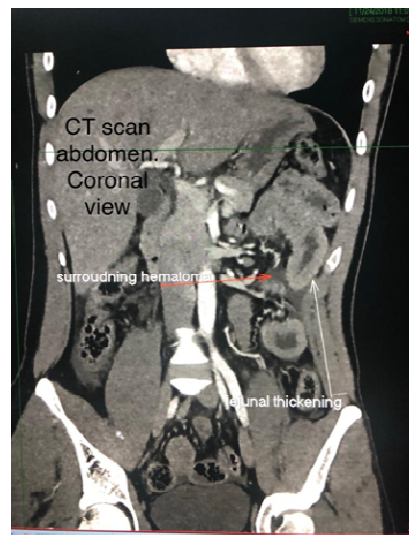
CT scan abdomen Coronal view
